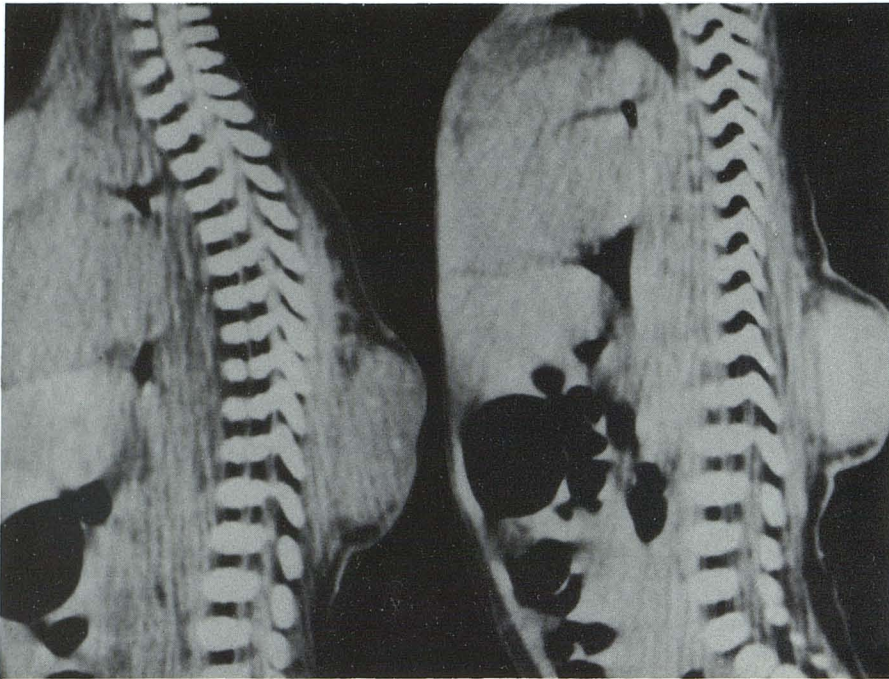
Case 5. Capillary hemangioma. Postmetrizamide direct sagittal CT scans before (*left*) and after (*right*) administration of contrast material. Large but discrete extraspinal hemangioma enhances.
